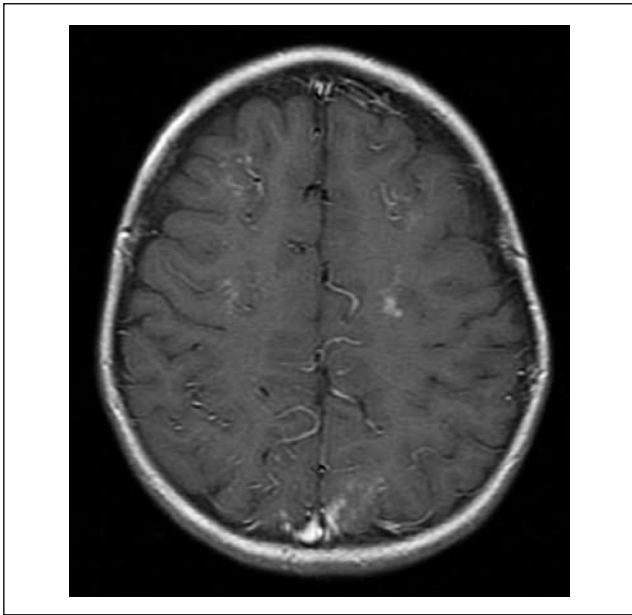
A 4-year-old-boy with severe headache for a few days before examination, without neurological signs and symptoms. He has a history of acute lymphoblastic leukaemia. CT scan one day before MRI – normal. MRI, SE/T1-weighted image after gadolinium administration. Contrast enhancement within the cortical grooves and parenchymal. MRI indicates leukaemic infiltration (recurrence) or neuroinfection.
